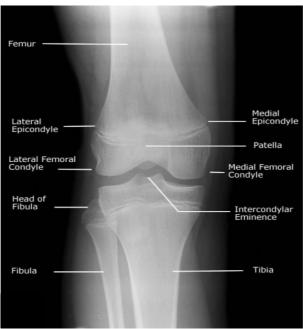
Plane radiograph of the adult knee anteroposterior view. Shadows of lower end of femur and upper ends of tibia and fiula. Rounded radiopaque shadow at the lower end of the femur superimposing the lower end of the femur is that of patella.
